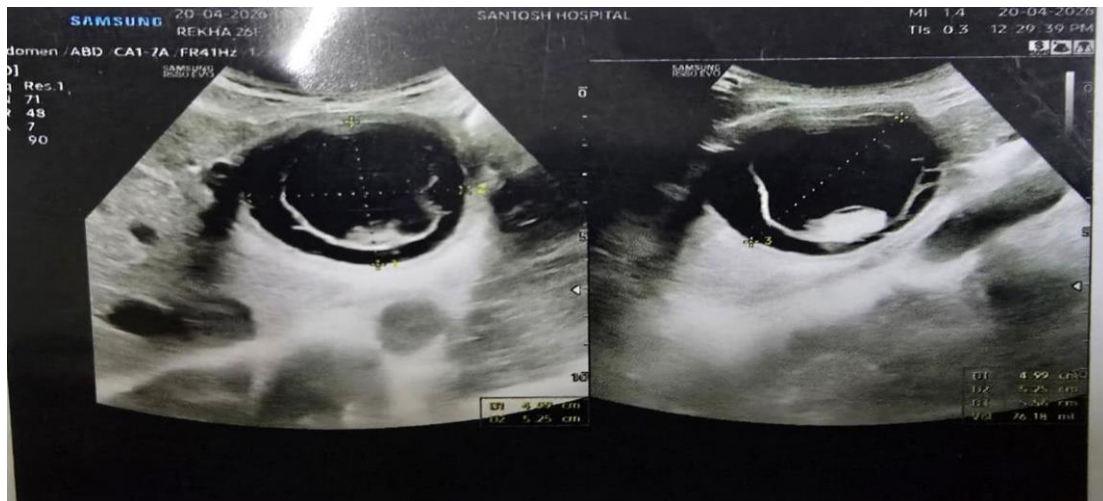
Ultrasonogram abdomen showing Hydatid cyst in left lobe of liver
